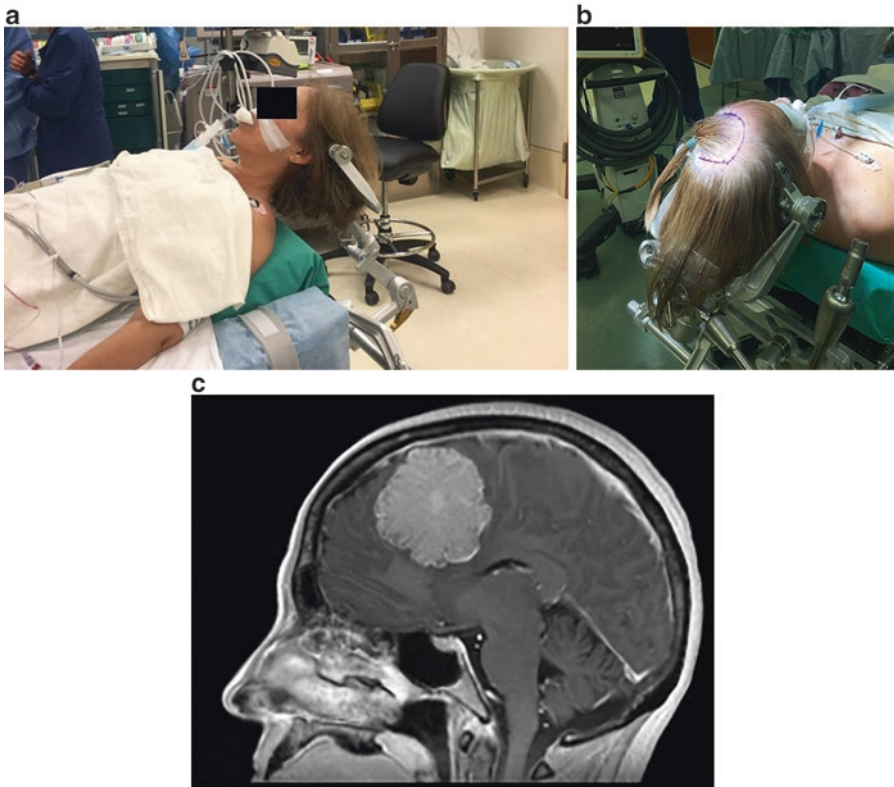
Supine position (a and b) of patient undergoing a craniotomy for a lesion in the left frontal lobe depicted in the MRI (c)
